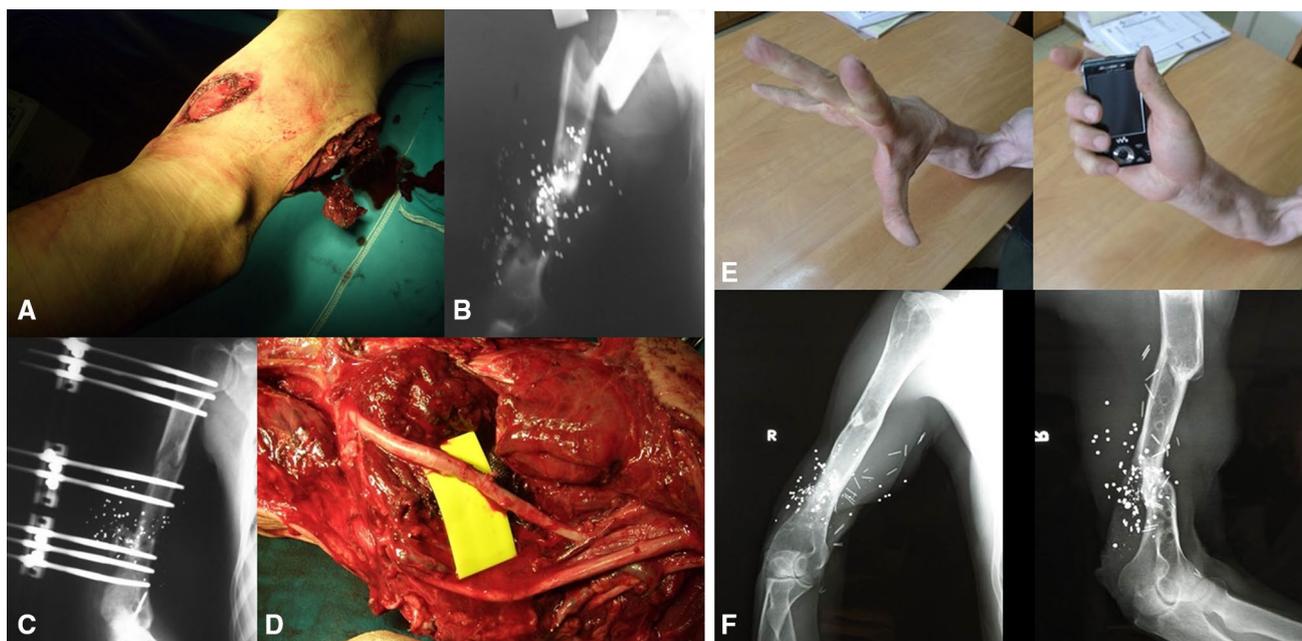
a Intraoperative photograph and b radiograph of the right humerus of a 33-year-old man with open comminuted fracture of the humerus, brachial artery tear and radial nerve transection after a gunshot injury by a hunting gun. c External fixation for bone stabilization, followed by d microsurgical repair of the brachial artery with a venous graft, and late (at 6 months) tendon transfers for the radial nerve palsy was done. Two years after the injury (e) hand function was good; f radiographs showed fracture healing
